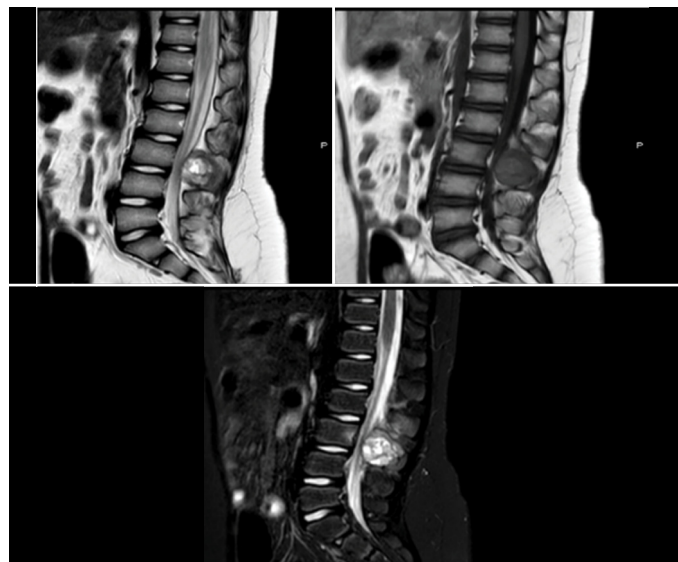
Sagittal MRI in T2, T1, and STIR sequences with contrast. Note the lesion in the L3/L4 region, hypointense in T1 and hyperintense in T2 and STIR.
